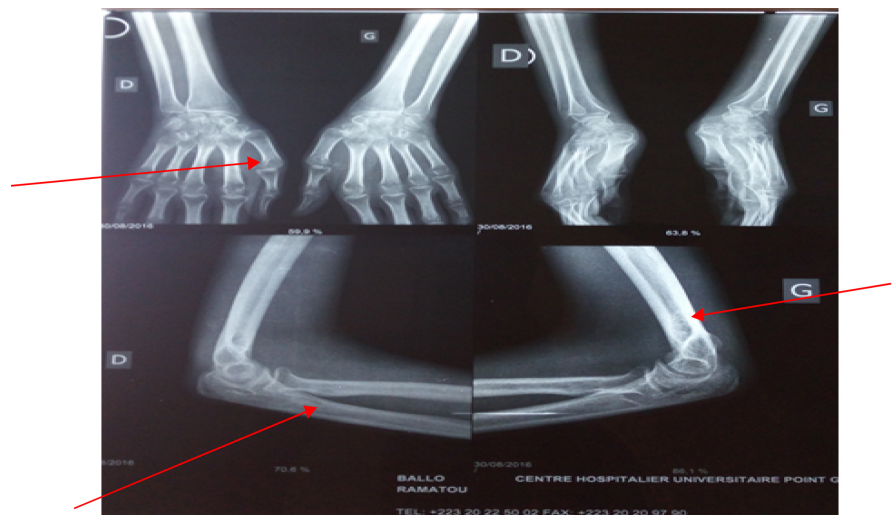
Bone radiograph of wrists and elbows: shows bone demineralization.
